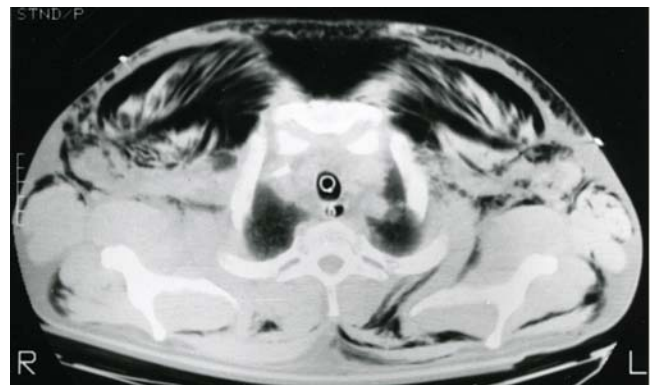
Example of widespread subcutaneous emphysema in a patient with barotrauma complicating ventilator management in severe ARDS. CT image through the shoulders, at the most cephalad extension of the lung apices, showing air widely dispersed under the skin and outlining the musculature.
